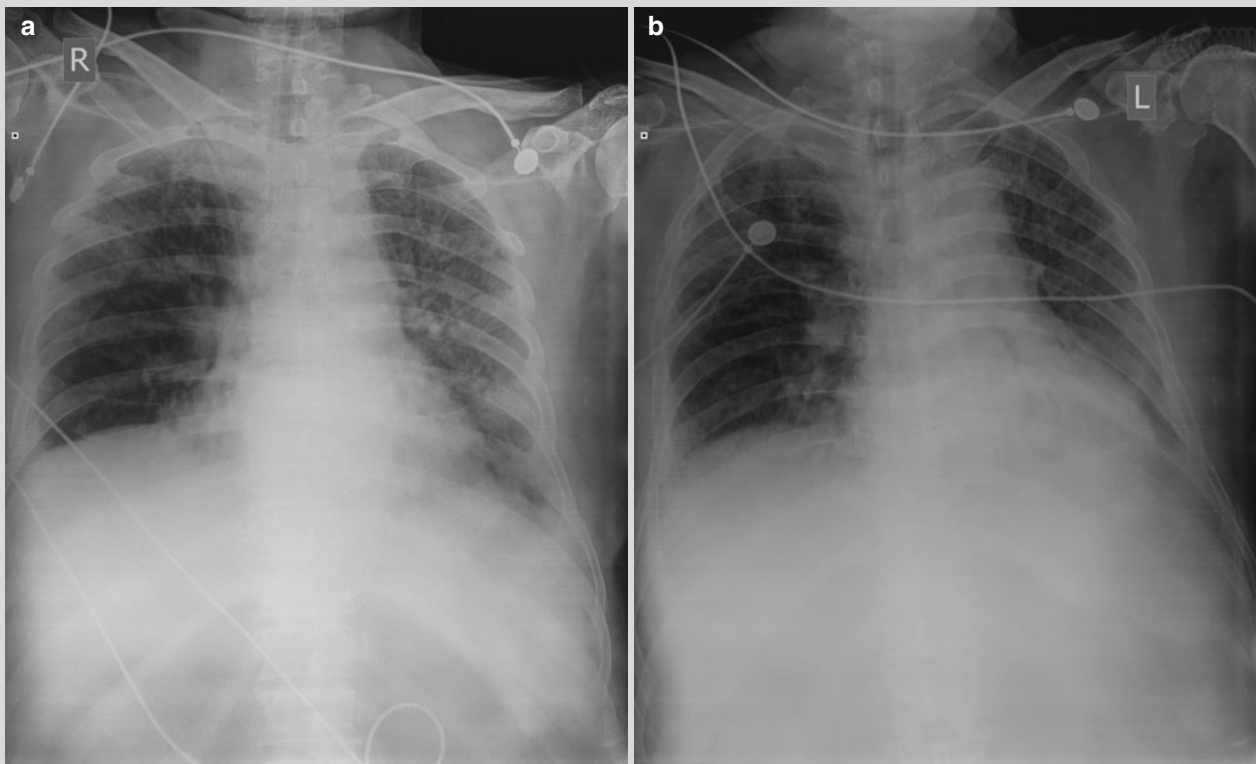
Chest X-ray demonstrated diffuse small patches of dense opacity in both lungs that are ground glass like (a). Re-examination after 1 day showed diffuse small patches of dense opacity in both lungs that are ground glass like, with no obvious change compared to the previous chest X-ray (b). Re-examination after 3 days revealed diffuse small patches of dense opacity in both lungs that
